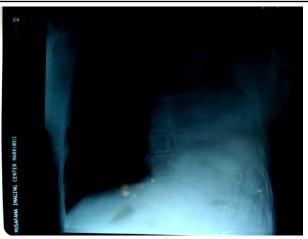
Chest radiograph showing complete opacification of the left hemithorax.
